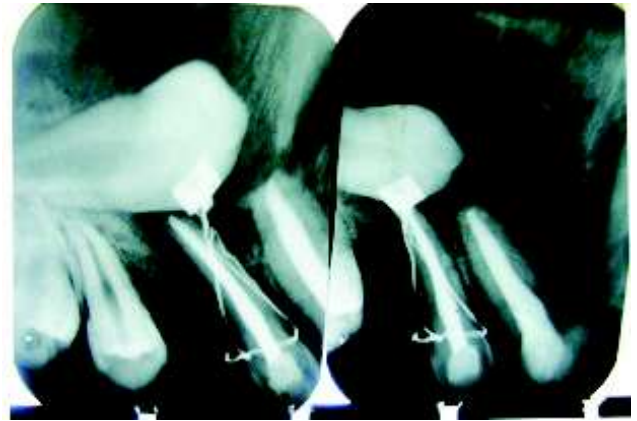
Immediate post-operative IOPA radiograph
